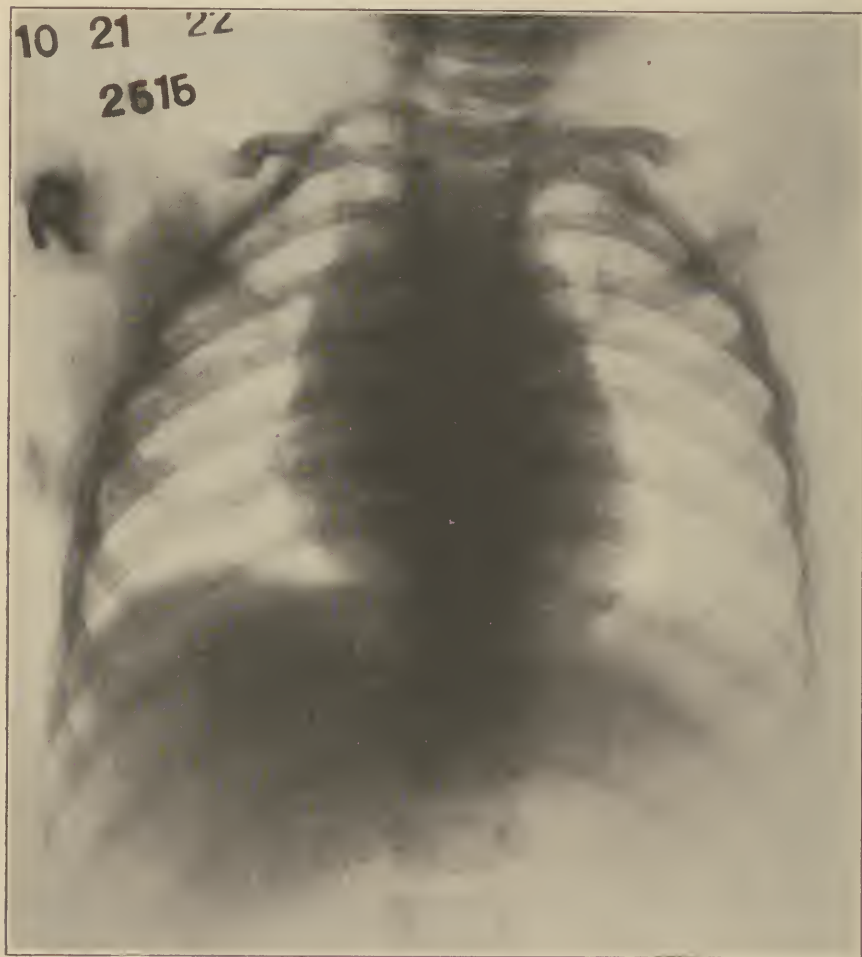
Radiograph of chest of child 20 months old, with an enlarged thymus gland.
